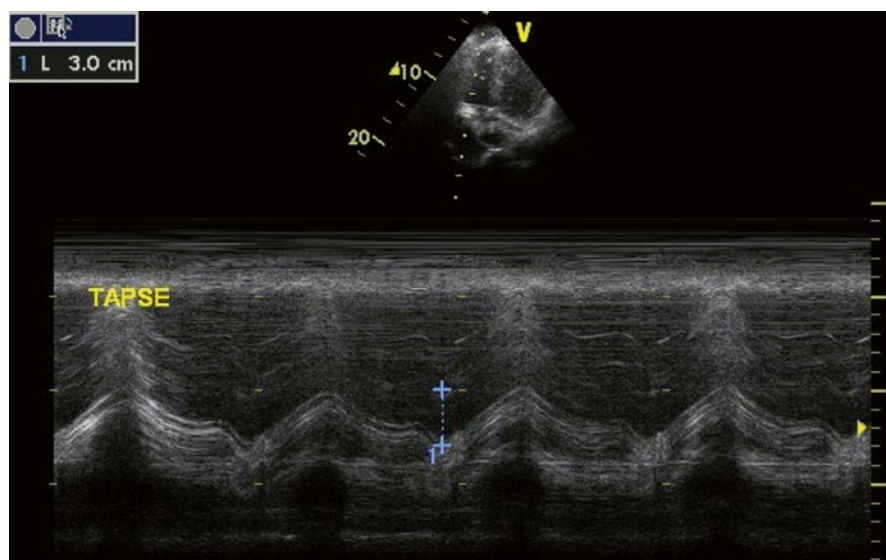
Tricuspid annular plane systolic excursion (TAPSE) determination using M-mode in the apical four-chamber view
